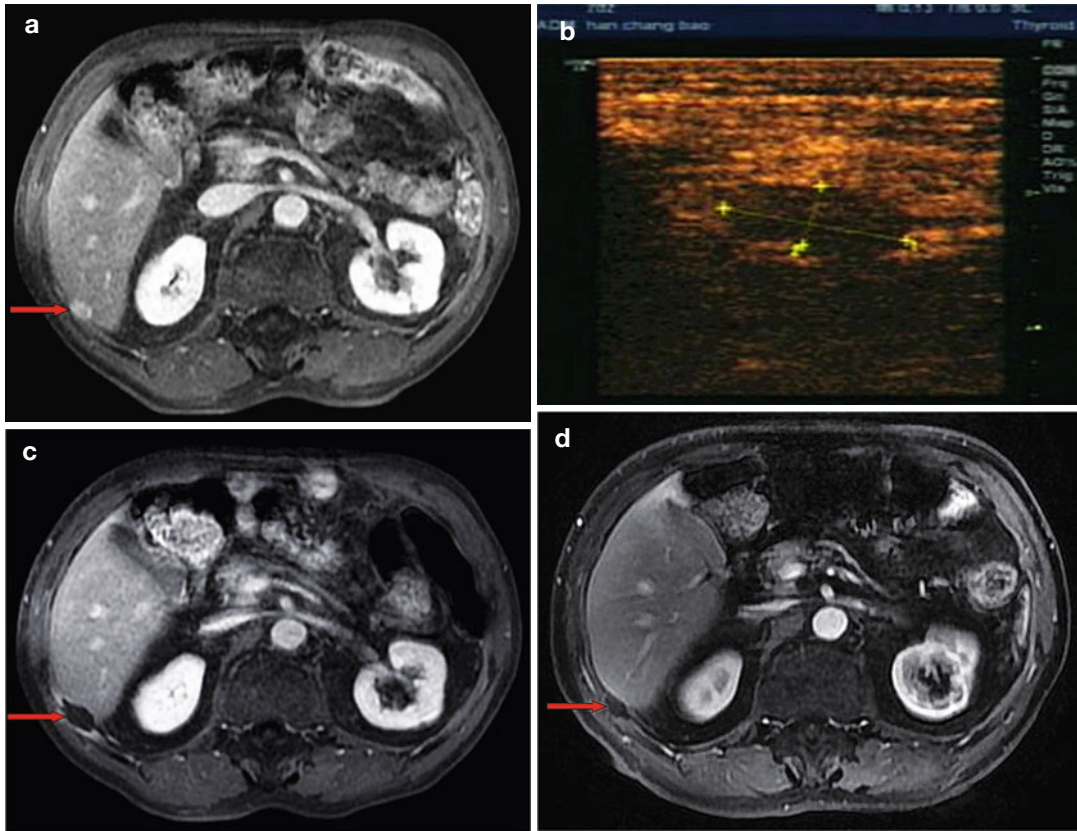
Microwave ablation (MWA) in a 71-year-old man with right abdominal wall metastatic tumor, post operation of colon cancer, splenectomy of spleen metastasis, and radiofrequency ablation (RFA) for the liver metastasis. (a) Pre-ablation arterial-phase magnetic resonance imaging (MRI) scan shows one round-like enhancement neoplasm (*arrow*) near the right abdominal wall with the size of 2.2×1.4 cm. (b) Contrast-enhanced ultrasound
